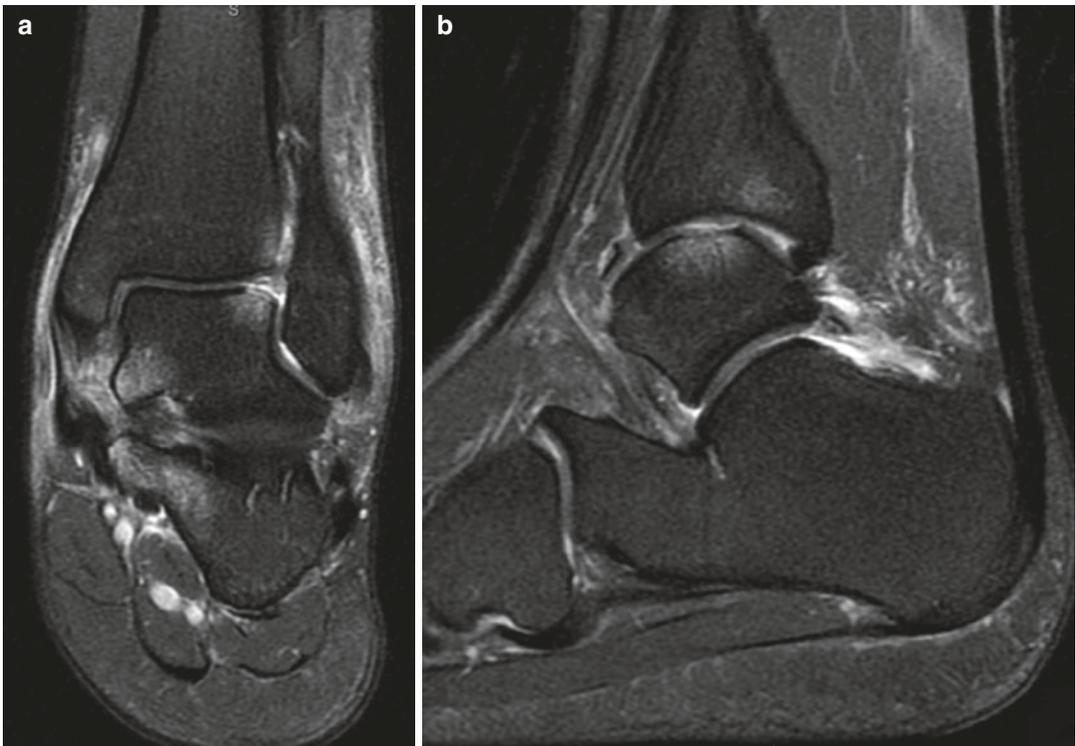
Fat-suppressed proton-density-weighted coronal (a) and sagittal (b) MRI images of a lateral-central OLT
